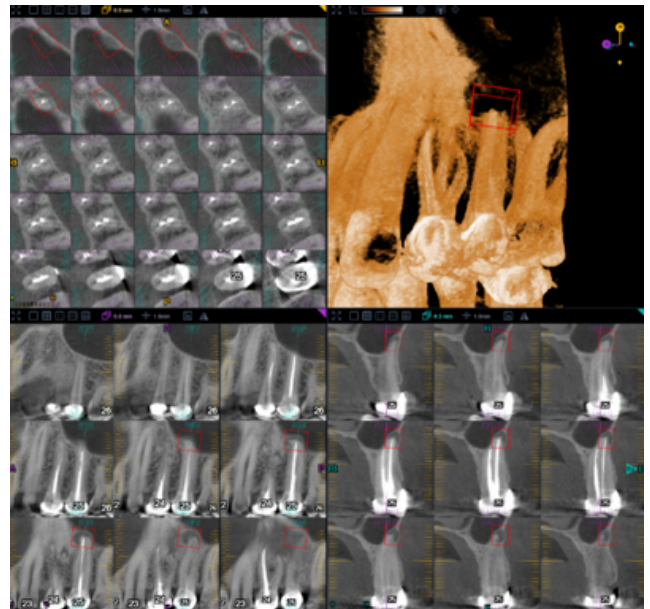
Three-dimensional cone-beam computed tomographic (CBCT) of tooth #25 showing three fused roots and periapical pathology in relation to the buccal roots.
